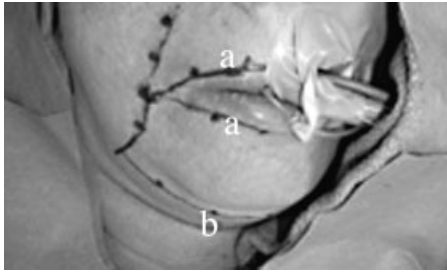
Facial artery Dopplered with areas of increased signal marked with dots. These dots represent cutaneous perforators coming from the underlying facial artery. Note the extension along the labial arteries (a) as well as along the submental artery (b).
